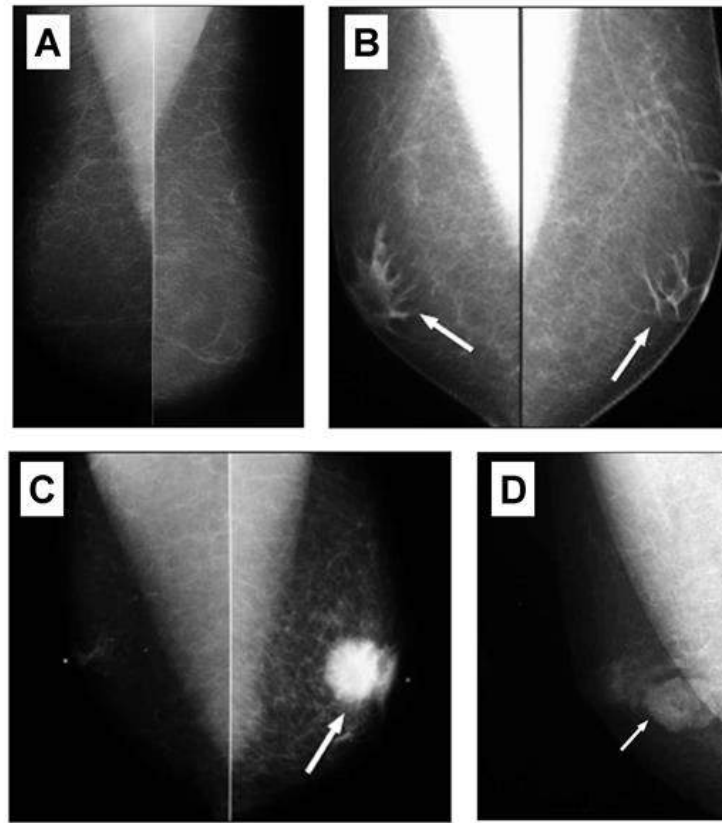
Radiographic appearances of benign and malignant male breast disease: a) normal - mediolateral oblique mammograms of both breasts in a male b) gynecomastia - showing linear or flame-shaped projections (arrows) that radiate out into the fatty tissue, c) invasive ductal carcinoma - showing round high-density mass (arrow) with irregular margins and subtle spiculation in the retroareolar region, d) invasive papillary carcinoma - showing a circumscribed oval mass (arrow) with lobulated margins and associated microcalcifications with gynecomastia also present in the retroareolar region. Adapted from Yitta S *et al.*(115).
